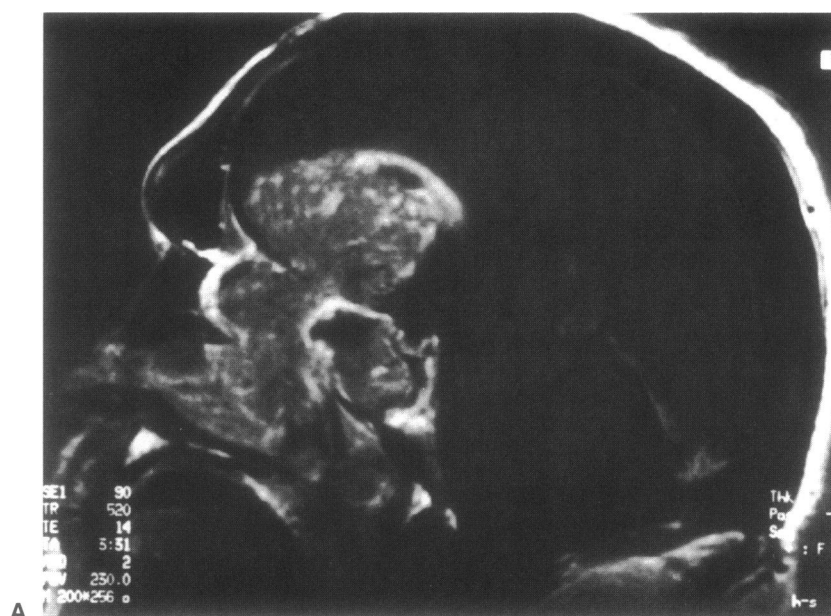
Sagittal (A) and coronal (B) T1-weighted MRI scans with gadolinium contrast demonstrating extensive paranasal sinus, orbital, and skull base involvement of a mucoepidermoid carcinoma in a 43-year-old man. This patient underwent complete resection with orbital exenteration and latissimus dorsi free flap reconstruction without postoperative complications.
